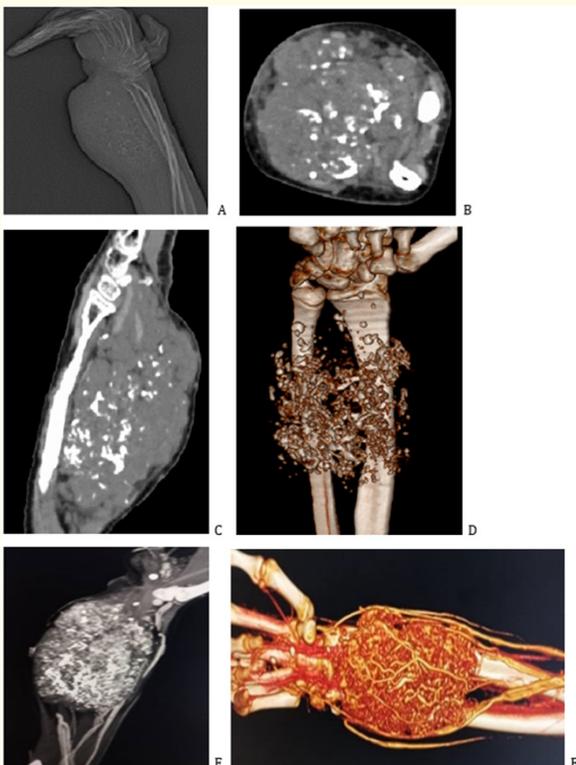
CT images: A Topogram, B axial section PB, C sagittal reconstruction PB, D volumetric reconstruction, E angiotac reconstruction, F volumetric reconstruction angiotac where cavernous hemangioma is evident.
